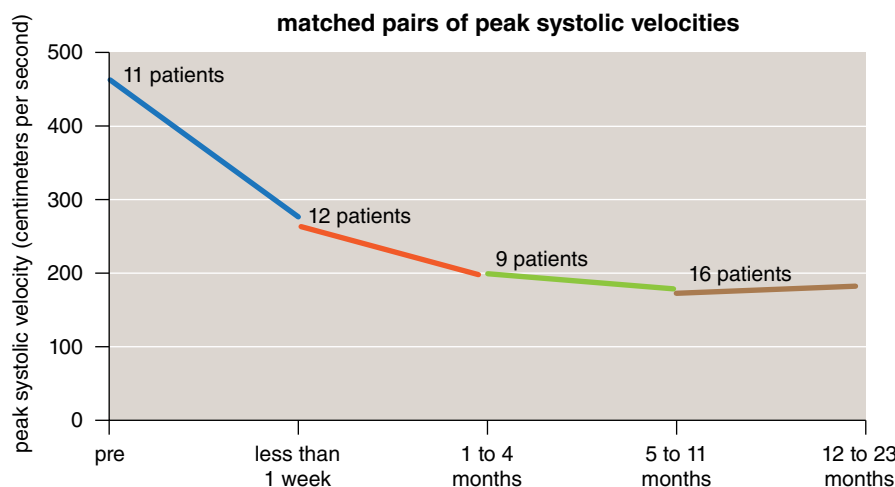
Ultrasound imaging of a stented carotid artery shows the points measured to assess the effect of stents on the carotid artery wall thickness and overall artery diameter (top). The luminal diameter (inset) shows the internal size of the artery. Plaque thickness was shown to decrease after stent placement, but overall artery diameter did not change, indicating that the stent had remodeled the plaque but not displaced the normal artery wall. Ultrasound tests on the authors' first 21 patients with self-expanding stents also allowed flow comparisons of the rate of blood flow within the vessel (peak systolic velocity) before and after stent placement (bottom). Peak systolic velocity above 250 centimeters per second is considered severe. These results showed that the internal diameter of the vessel was indeed being opened by the stent, rather than the stent embedding itself into the plaque.
